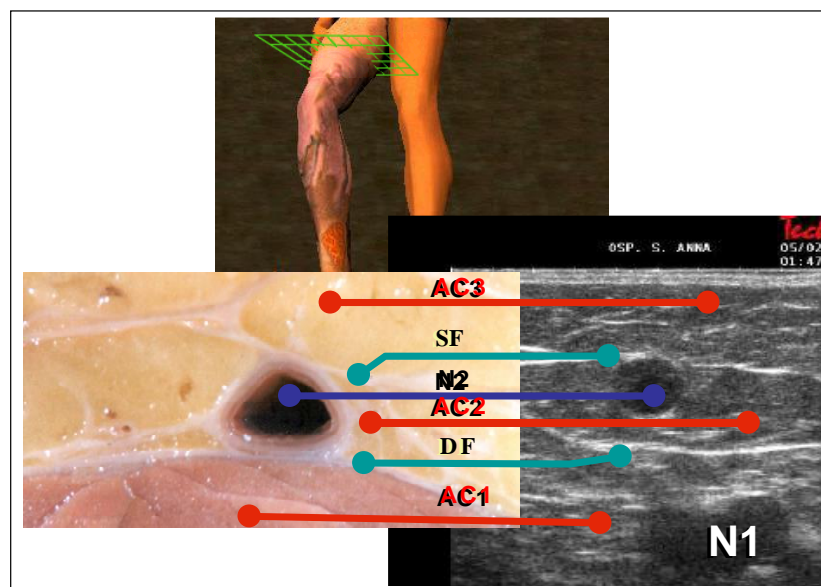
Anatomical and ultrasonographic transverse access of the medial aspect of the thigh.
